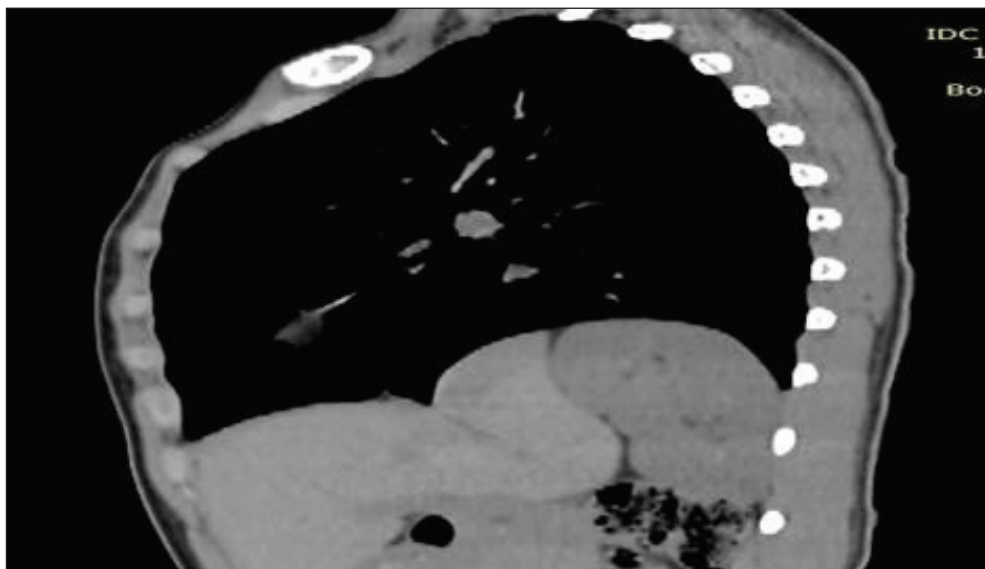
CT sagittal view showing right thoracic kidney and eventration of the right hemidiaphragm.
